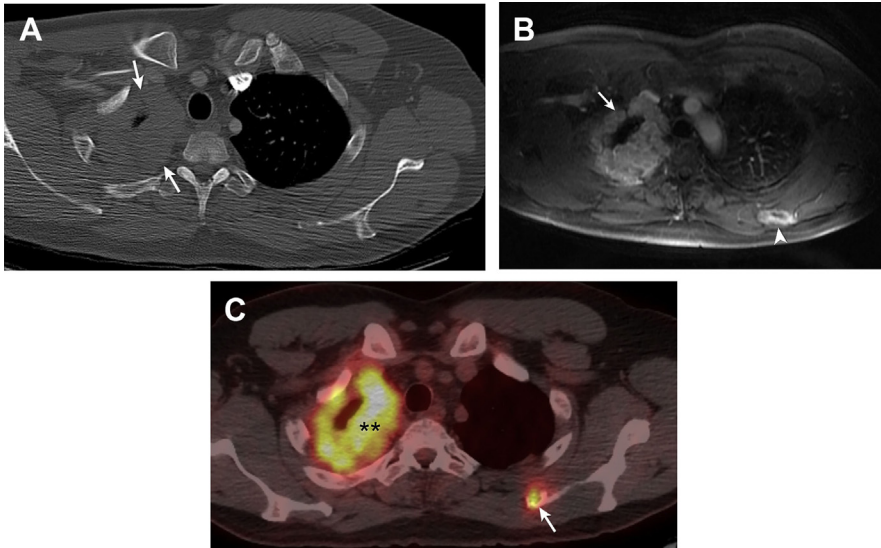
M1b disease. (A) Contrast-enhanced axial CT of the chest demonstrates concentric right pleural nodular thickening (*arrows*) consistent with pleural metastatic disease from thymic carcinoma (not shown). (B) Axial T1-weighted fast spin echo with fat saturation MR image after the administration of paramagnetic intravenous contrast, performed 3 days following the CT, shows the right circumferential pleural metastatic disease (*arrow*) and an enhancing left scapular metastasis (*arrow head*). With its superior contrast resolution, MR imaging is a valuable tool in the assessment of the chest wall and soft tissues and in identifying distant metastatic disease that may be overlooked on CT. (C) Fused axial FDG PET/CT shows marked FDG uptake in the metastases to the pleura (*double asterisk*) and scapula (*arrow*), typical of thymic carcinoma.
